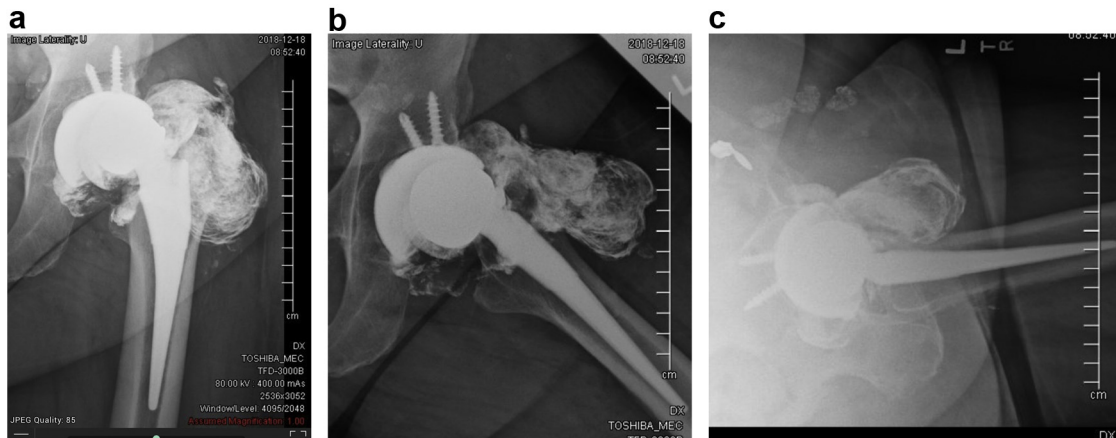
Antero posterior (a), frog lateral (b), and cross-table lateral (c) radiographs of a failed oxidized zirconium THA with polyethylene liner dissociation and resultant Oxinium “arthrogram.”
